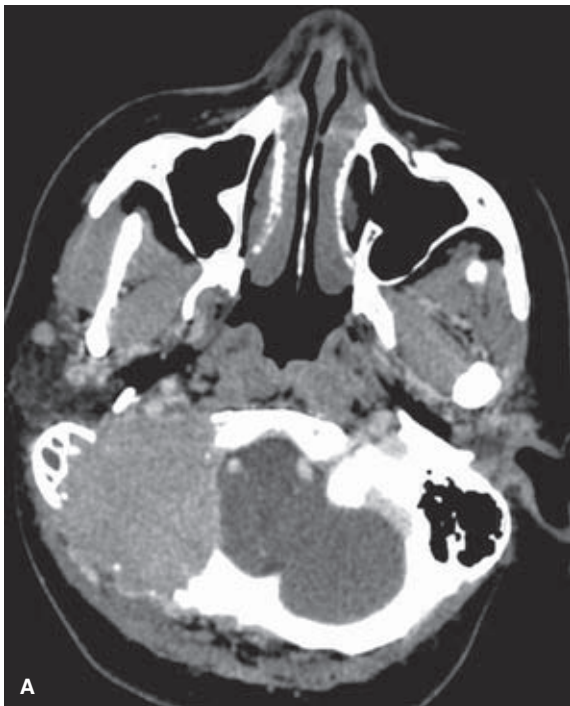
(A–B) Sometimes, the obvious is not so easy to see. This elderly patient was billed as a preoperative embolization of a posterior fossa meningioma. There is a smoothly enhancing lesion on the contrast-enhanced CT scan (A) conforming with this diagnosis. The lateral occipital artery angiogram was interpreted as showing a typical “sunburst” radial pattern of vasculature consistent with meningioma, although in retrospect the vessels look a little more disorganized than is typical of meningioma. The pathology report stated plasmacytoma. In retrospect, the CT scan shows a great deal more bone replacement by tumor than should be the case for simple meningioma.
